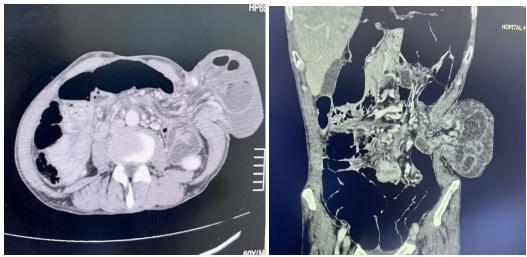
Abdominal CT scan image
